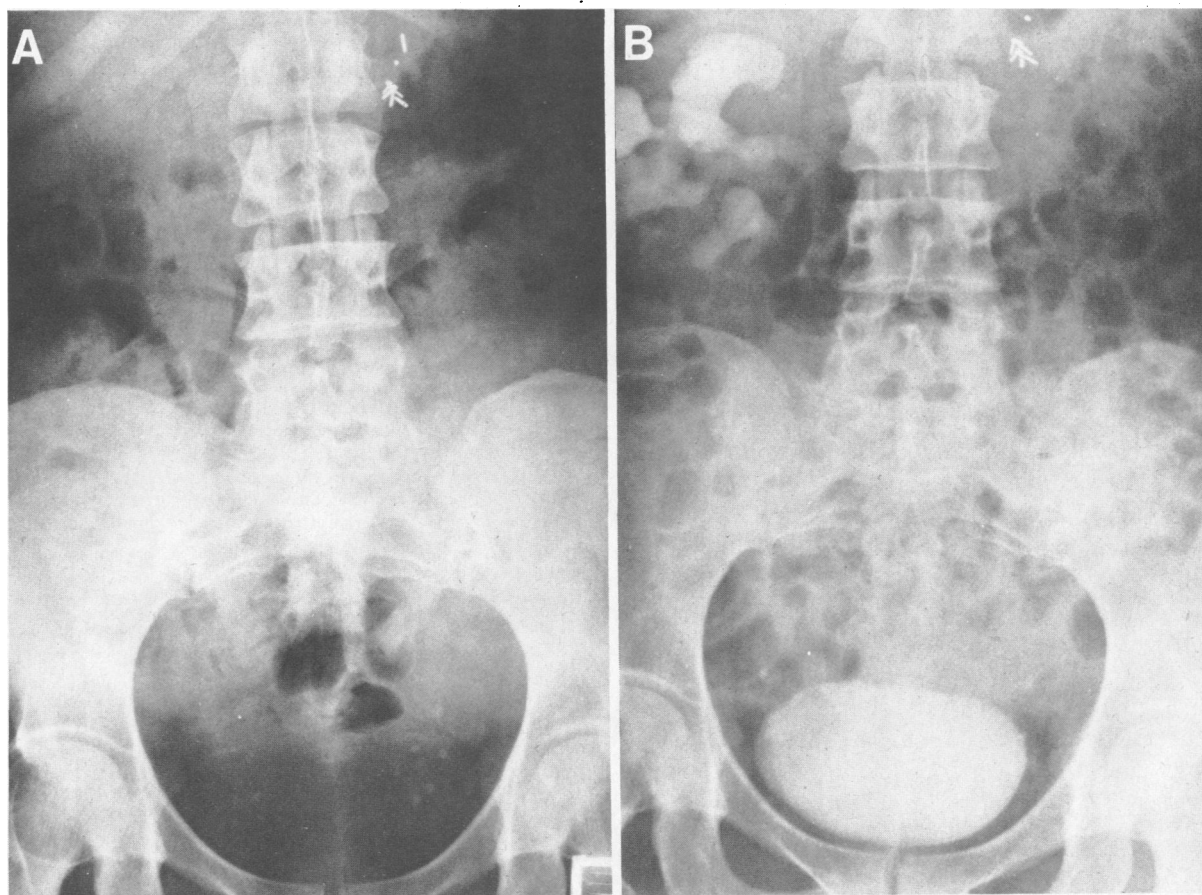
(Case 2) A, Postoperative plain film showing no stones present. B, Excretory urogram two months after left nephrectomy and right nephrolithotomy with lower pole nephrectomy showing improvement in both obstruction and function.
